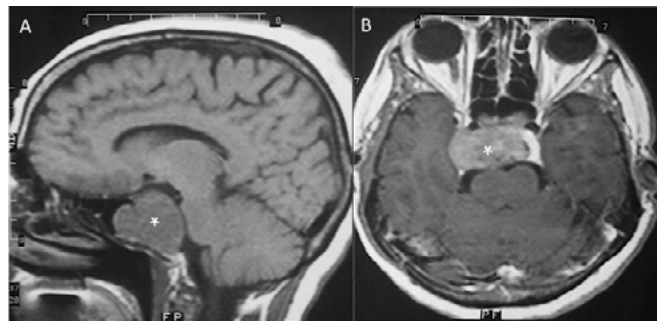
T1-weighted magnetic resonance imaging: (A) sagittal view and (B) axial view (with gadolinium enhancement) showing the pituitary macroadenoma with massive suprasellar extension and invasion to the sphenoid and cavernous sinuses mainly on the right side.
